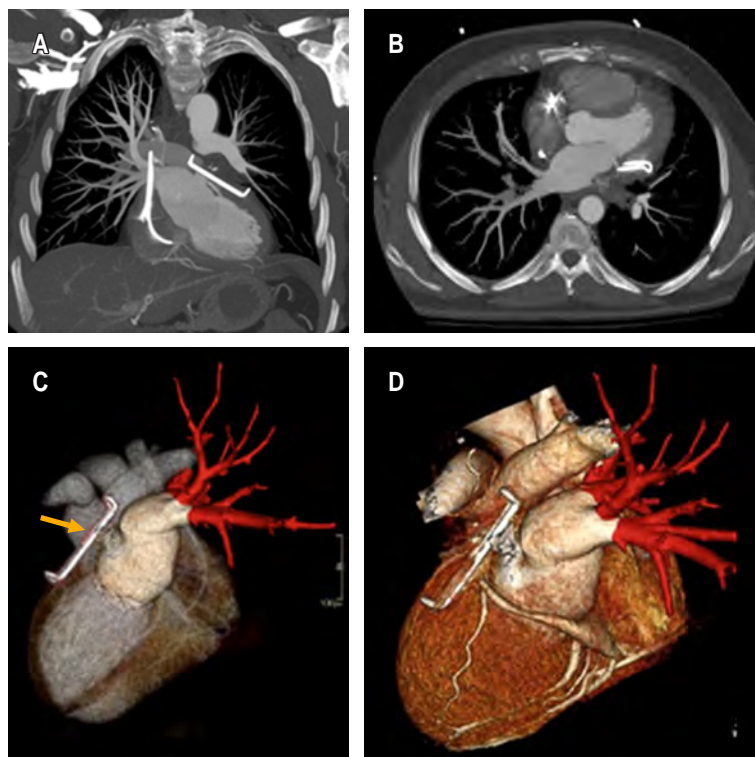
Images corresponding to a computed tomography angiography with intravenous contrast in systemic arterial phase. The greatest contrast opacification can be seen in the pulmonary venous tree and in the systemic arteries. A) Axial MPR image with a thickness of 40mm showing the asymmetry of the pulmonary vascularization, as well as the absence of left pulmonary veins draining into the left atrium. B) MPR with a thickness of 40 mm showing the same findings as in A). Metal clip on the left appendage. C) 3D image of the cardiac volume. Posterior view of the heart. Transparency of cardiac chambers. Left atrium colored white. Right pulmonary veins colored red. Lack of visualization of left pulmonary veins due to its obstruction and therefore absence of contrast within it. Clip on left appendage indicated by arrow. Ascending aorta and pulmonary arteries in gray. D) 3D image similar to the previous one. Volumetric reconstruction of the cardiac surface. Posterior view of the heart.
